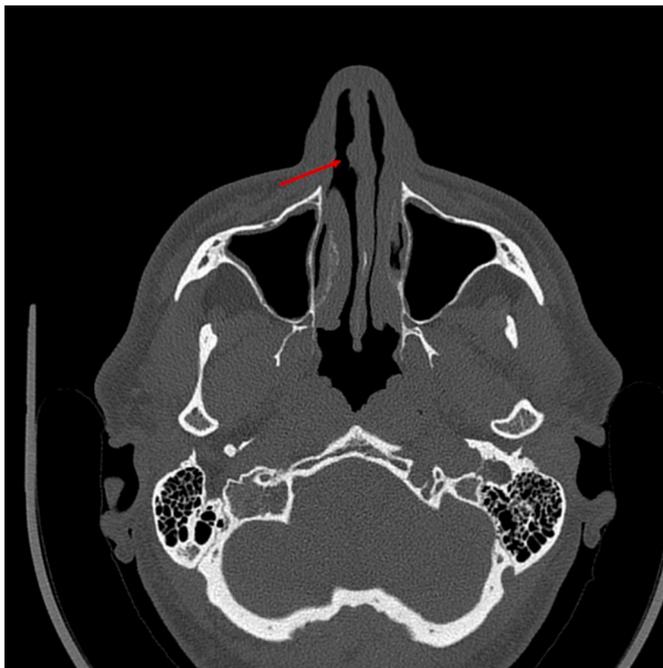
Case 1: CT scan showing a focal bulging formation of right lateral nasal septum (arrow).
